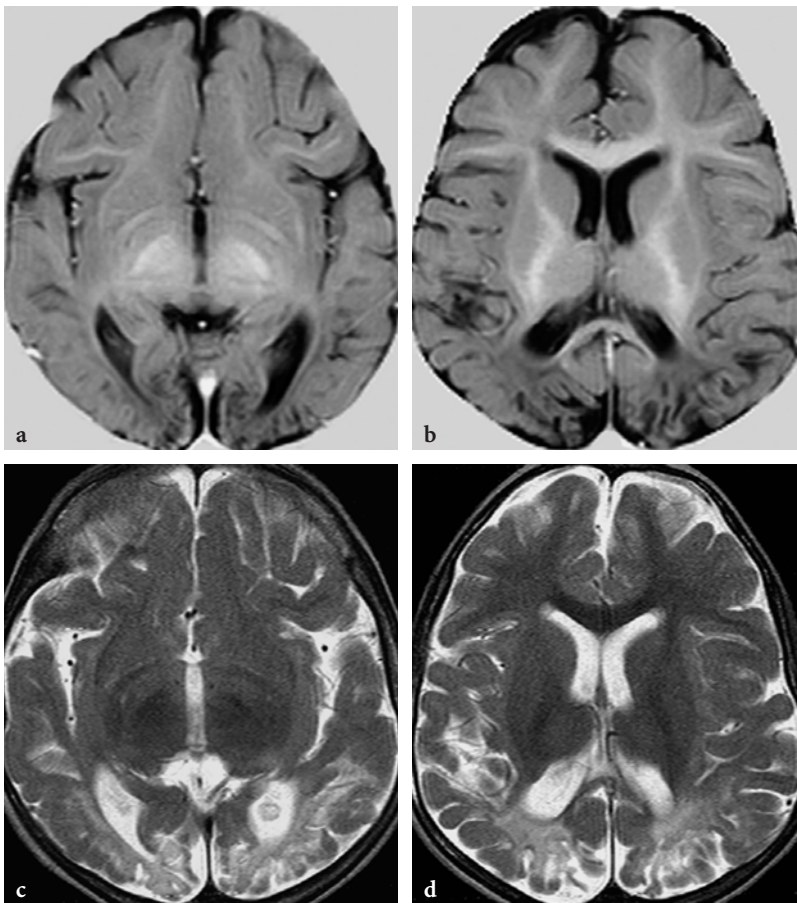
MR imaging findings in a male patient with medium-chain acyl coenzyme A dehydrogenase deficiency (neonatal onset form). a,b Axial T1-weighted inversion recovery images at the age of 1 year. Delayed and hypomyelination throughout the cerebral hemispheres. Bilateral symmetrical cortical-subcortical lesions exhibiting an atrophic character in the parieto-occipital regions. c, d Axial T2-weighted fast spin-echo images at the age of 2 years. There is some progression of the myelination, not fully accomplished though, but the parieto-occipital lesions are unchanged
